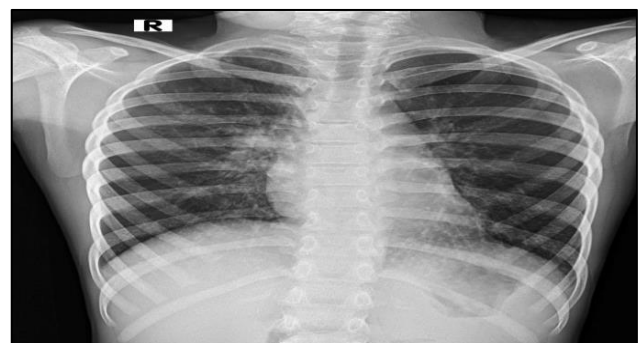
Chest X-ray showing emphysematous changes and normal laterality.
